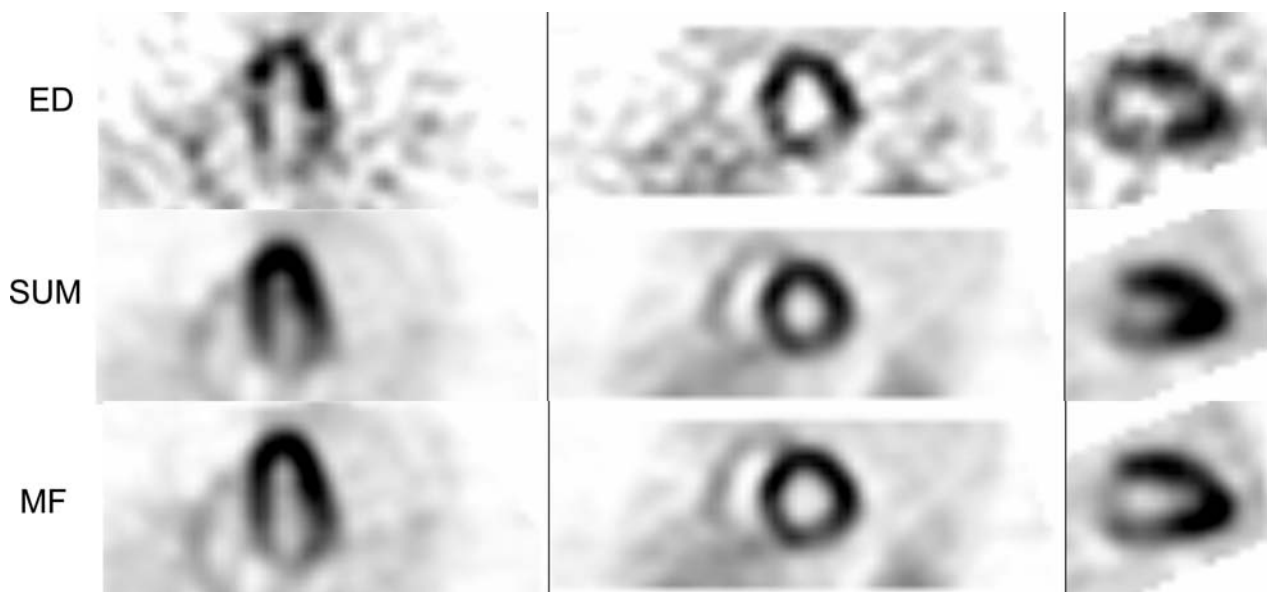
Short axis and vertical long axis of motion frozen (MF) reconstruction and standard summed reconstruction (SUM) of gated SPECT images. Motion-frozen perfusion images compared to the summed perfusion images in the case of double vessel disease confirmed by angiography (100% LAD occlusion and 80% LCX occlusion). Both standard quantification technique and visual analysis of summed data identified only the LAD lesion; the additional LCX lesion was identified only by the “motion-frozen” quantification. Reproduced with permission from Slomka et al.⁵⁶
